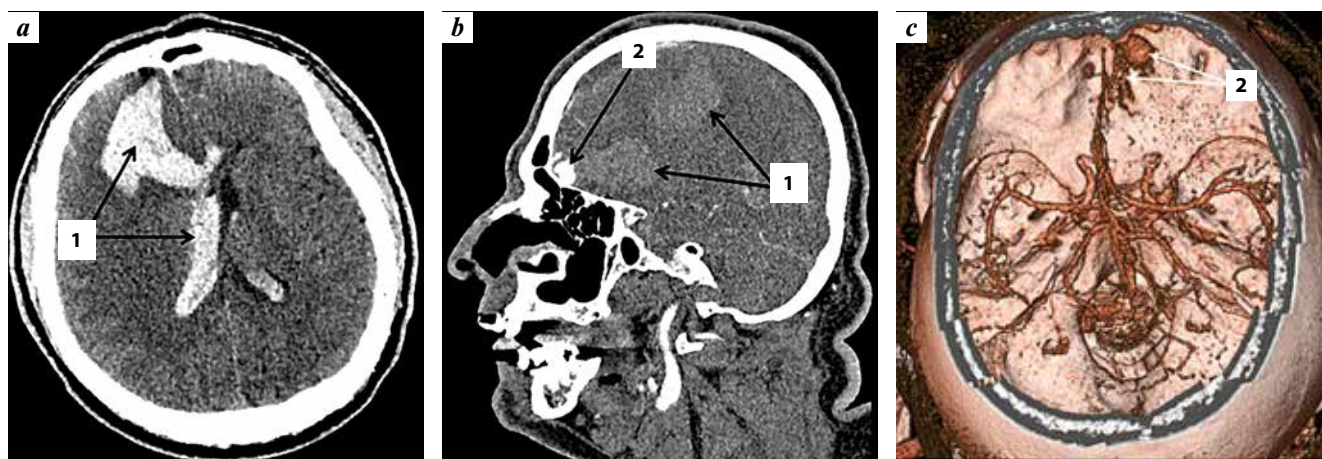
Computed tomography (CT) of the brain and cerebral CT angiography of patient U., 58 years old: a – brain CT, axial projection; b – multiplanar reconstruction (MPR); c – 3D shaded surface display (SSD). 1 – parenchymal intraventricular hemorrhage; 2 – ethmoidal dural arteriovenous fistula
